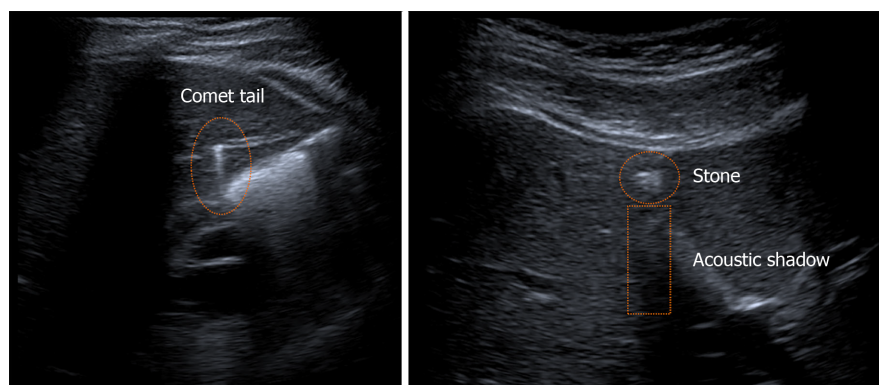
Ultrasound images of intrahepatic bile duct findings. Images courtesy of Dr. Karila-Cohen, Department of Radiology, AP-HP Bichat University Hospital, Paris 75018, France. This figure presents some of the intrahepatic bile duct findings detected via ultrasound imaging in our study. On the left: a comet-tail artifact. On the right: a stone and an acoustic shadow. These unpublished images are owned and were provided by Dr. Karila-Cohen.
